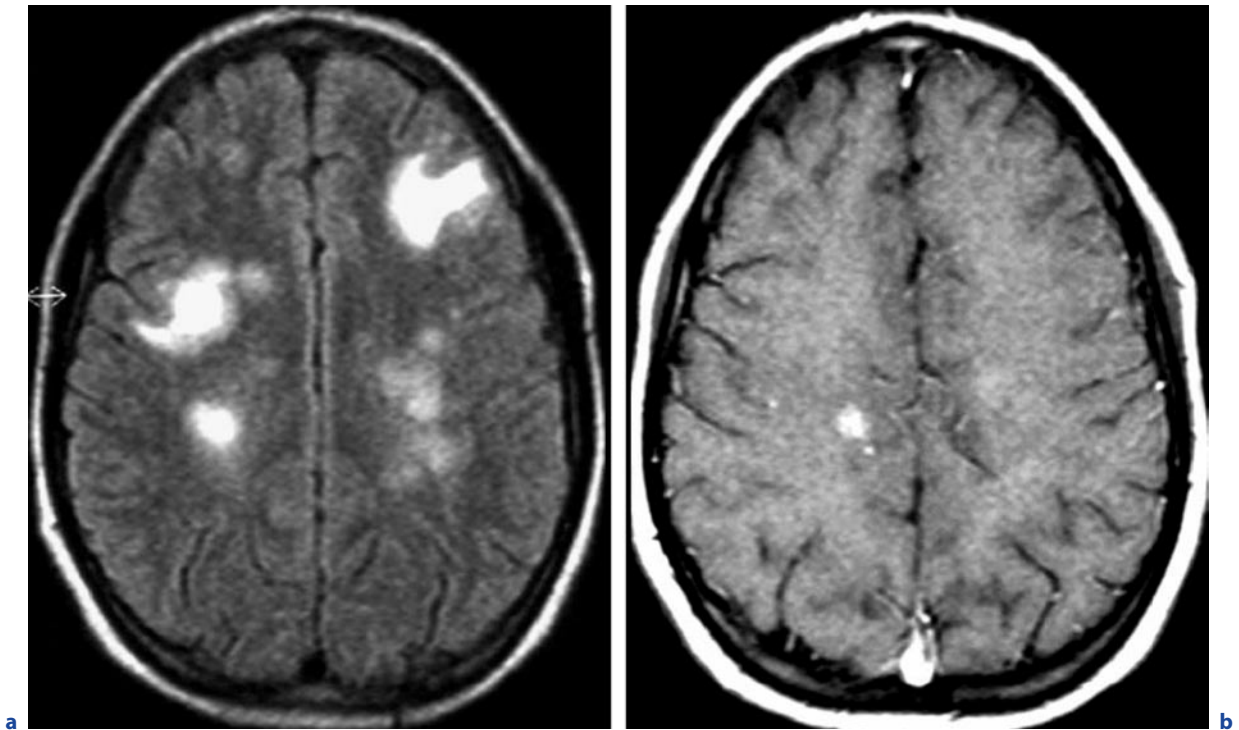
Acute disseminated encephalomyelitis. a Axial FLAIR image. b Axial T1-weighted image after contrast administration. Bilateral symmetric and subcortical lesions on FLAIR images, one of which reveals contrast enhancement
